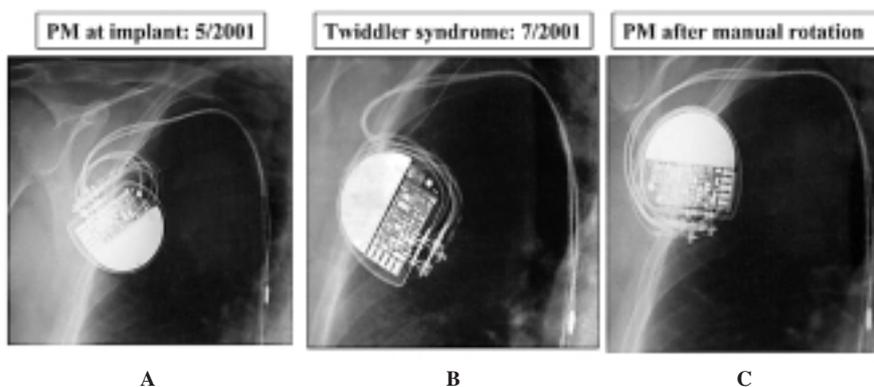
X-ray position of the pacemaker (antero-posterior view). A: original position of the pacemaker after implant (May 2001) with correct orientation of the lead connectors. B: Twiddler's syndrome after 2 months (July 2001) with rotation of the pacemaker case. C: pacemaker after restoration of the original position by external manual rotation of the case.
